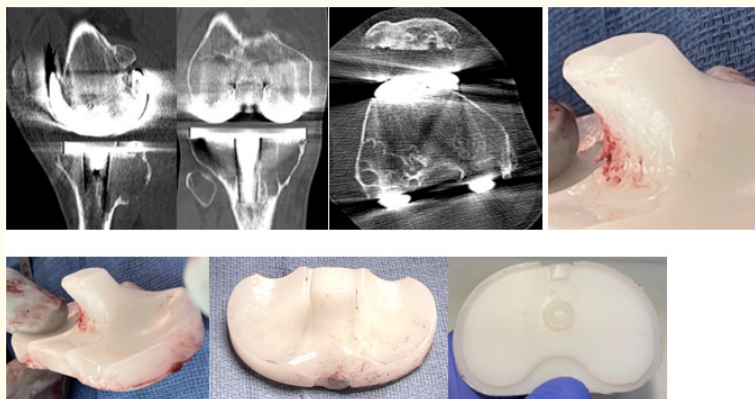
Case Example 1: Aseptic Revision. The first case was in a male competitive slalom water skier and surfer who had had multiple ACL reconstructions and revisions prior to his total knee. He underwent a right total knee replacement with patellar resurfacing, using Cemex fast set cement. At index surgery he was 51 years old, 5’1” and 188 lbs. He continued his vigorous sporting activities following his total knee surgery. Revision was required at 87 months because of the sudden onset of posterior medial knee pain. Infection workup was negative. An x-ray and CT scan revealed a large posterior lytic tibial lesion and a femoral lytic area. An avulsion fracture had occurred in the region of the semimembranosus tendon attachment. At revision, both lateral femoral and medial tibial osteolysis was found. Neither the femoral nor tibial components were loose although the femoral component was easily removed. Osteolysis was undermining both implants. The insert showed severe wear on the back of the tibial post and complete obliteration of the 0.5mm deep labeling on the anterior aspect of the insert backside. The time from insert packaging to index surgery was 21 months.
